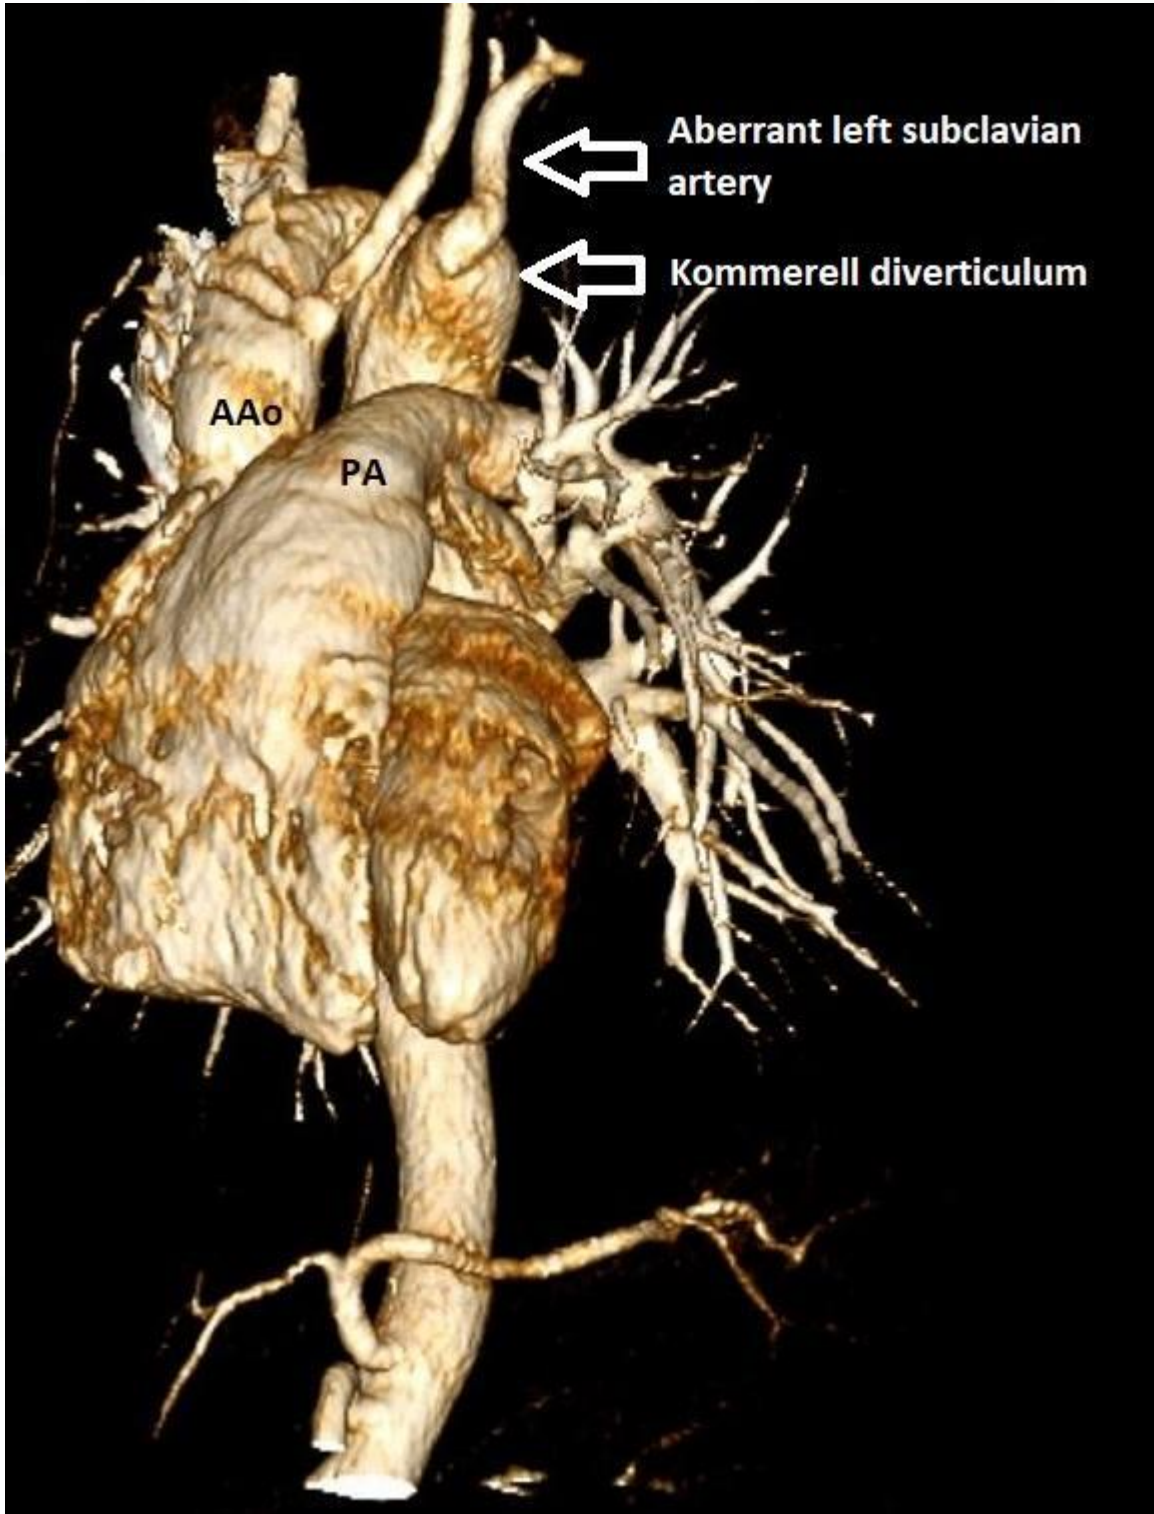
CT angiographic examination of the thoracic aorta reveals the right aortic arch extending from the descending aorta to the transverse aorta line (Kommerell diverticulum) and aberrant left subclavian artery was separated from the top of this structure.
